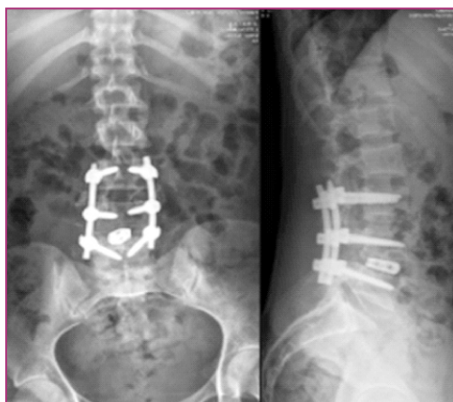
Post-operative radiograph AP & Lat. views of lumbar spine showing reduction and posterior instrumented fusion.
